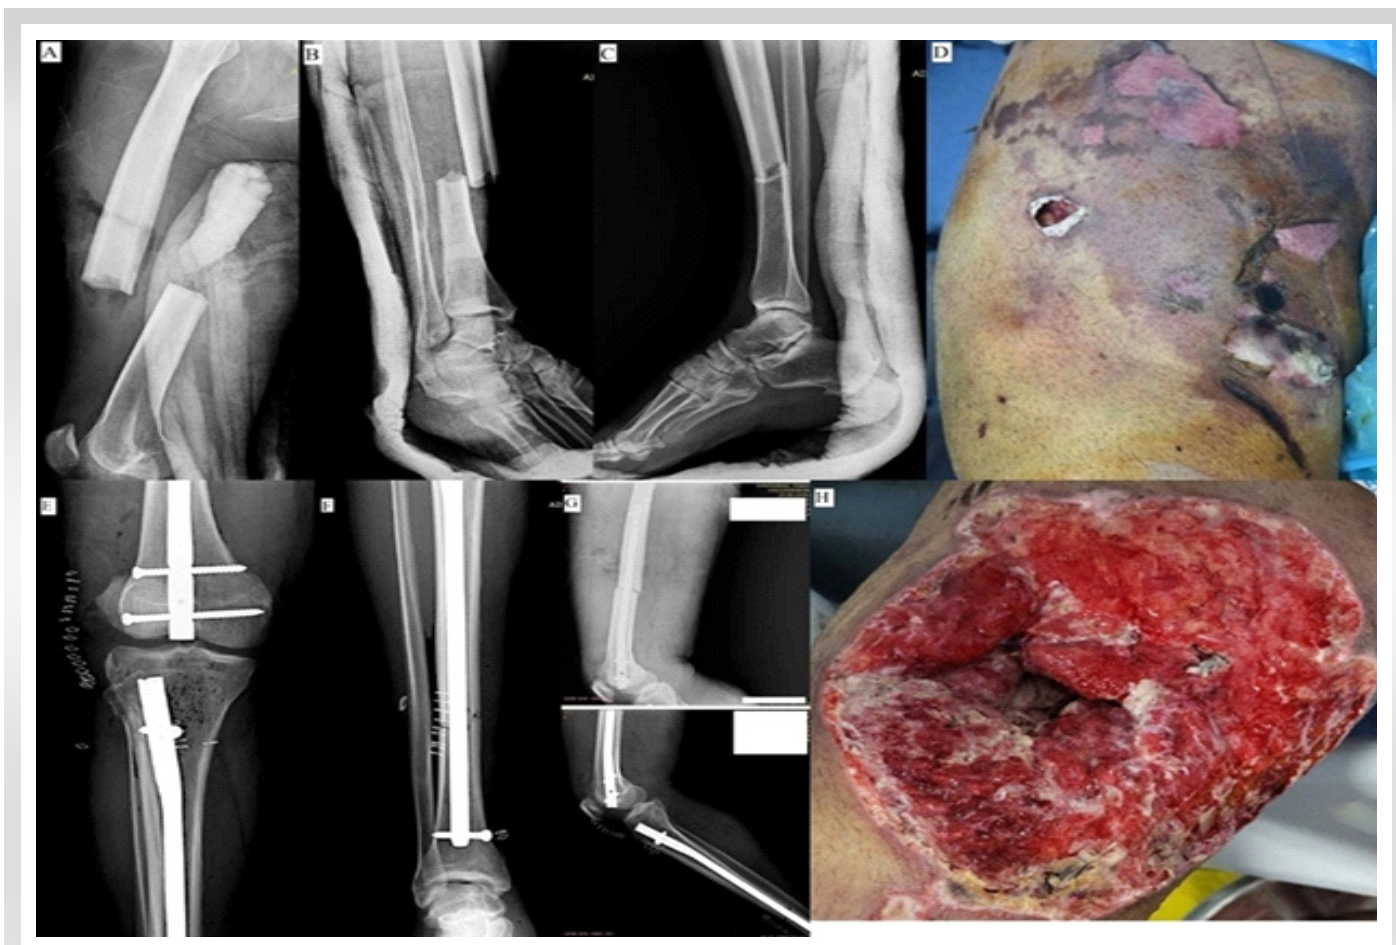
(a, b, c) Pre-operative X-rays; (d) Clinical representation of the injured thigh at the time of presentation; (e, f, g) Immediate post-operative X-rays; (h) Thigh wound following debridement (post-operative day 5).
